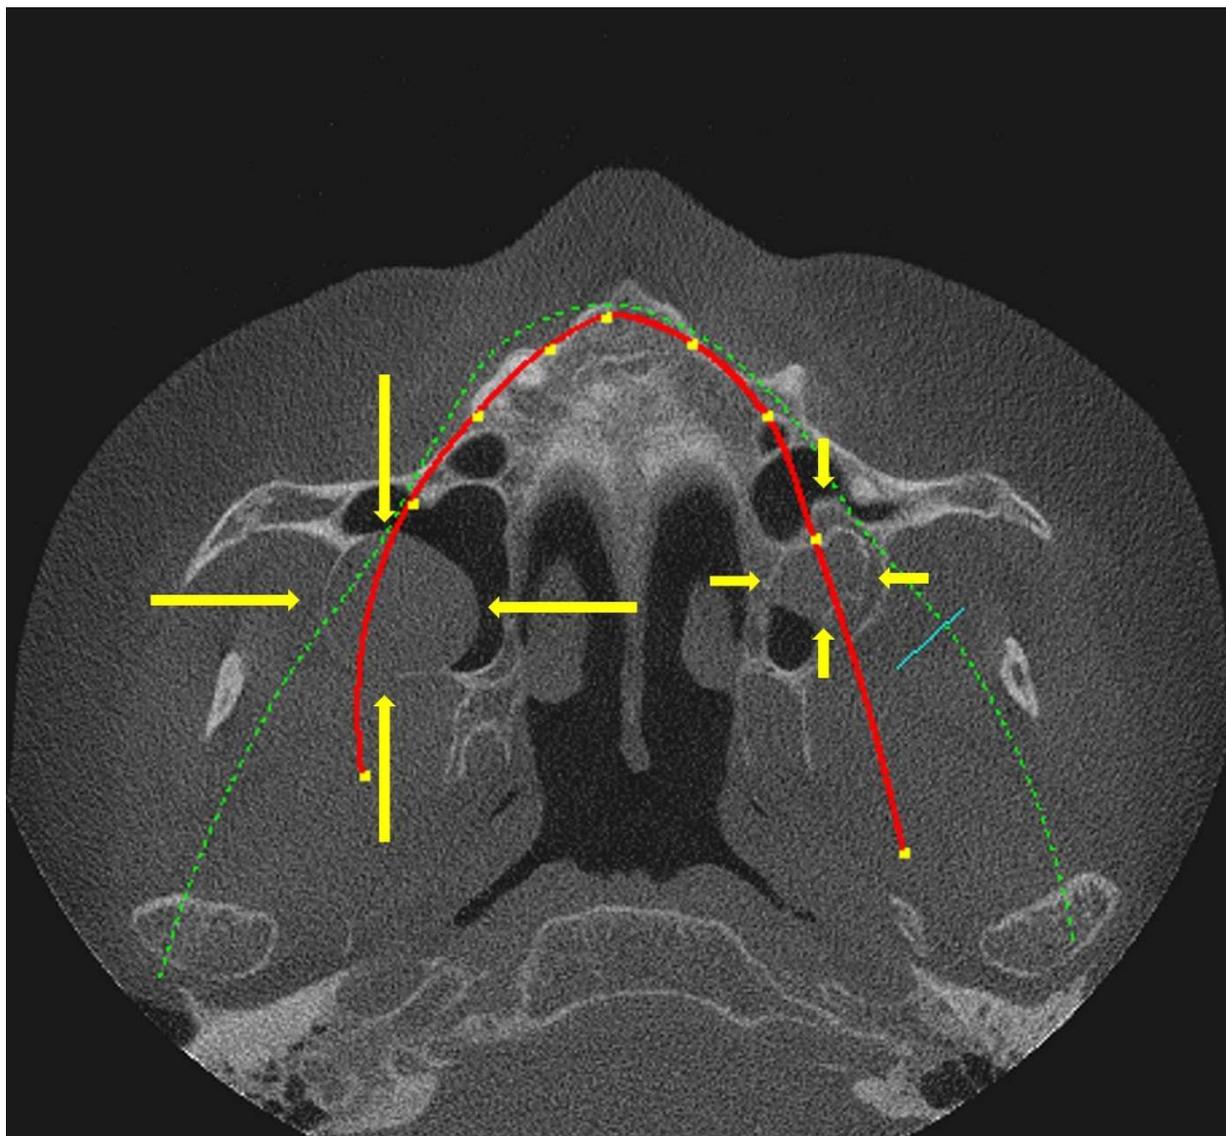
CBCT: Cyst left maxilla basal and right posterior sinus maxillaris.
